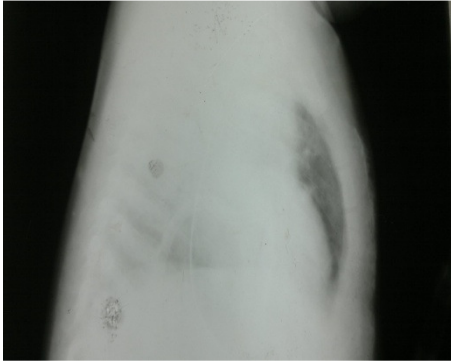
X-Ray showing the foreign body (pendant)
